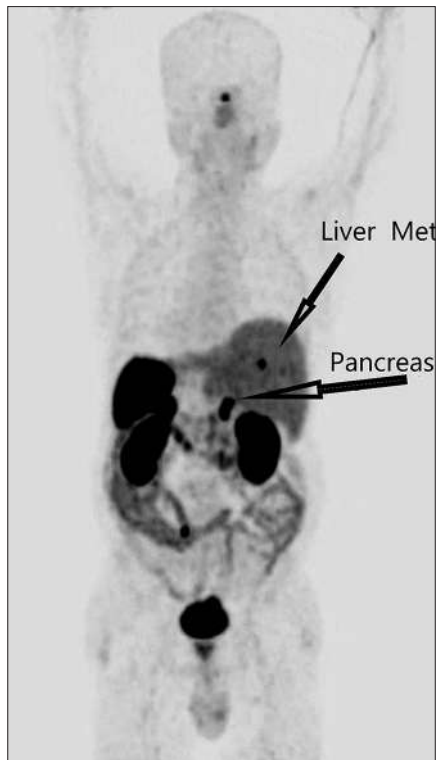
^{68}Ga -DOTATATE PET CT study of a 57-year-old gentleman who was diagnosed to have metastatic NET at baseline scan with uptake in segment 7 of liver and tail of pancreas as possible primary. Posterior view
